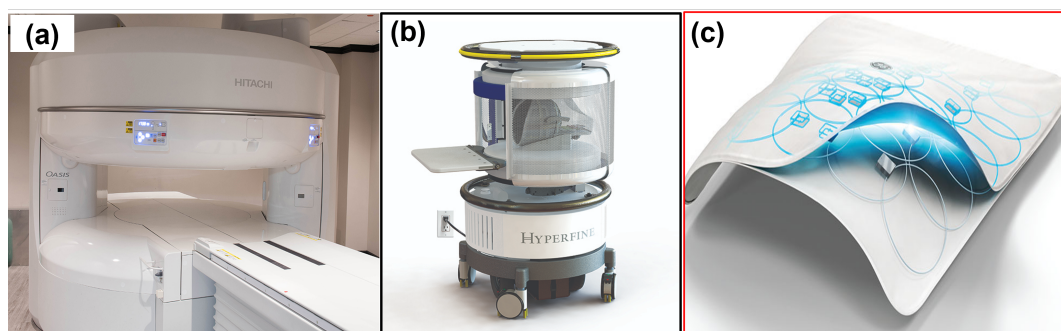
(a) 1.2T Open MRI scanner from Hitachi. Image source: [4]. (b) FDA-cleared portable MR imaging system from Hyperfine. Image source: [5]. (c) Flexible MRI receive coil from GE. Image source: [6].
